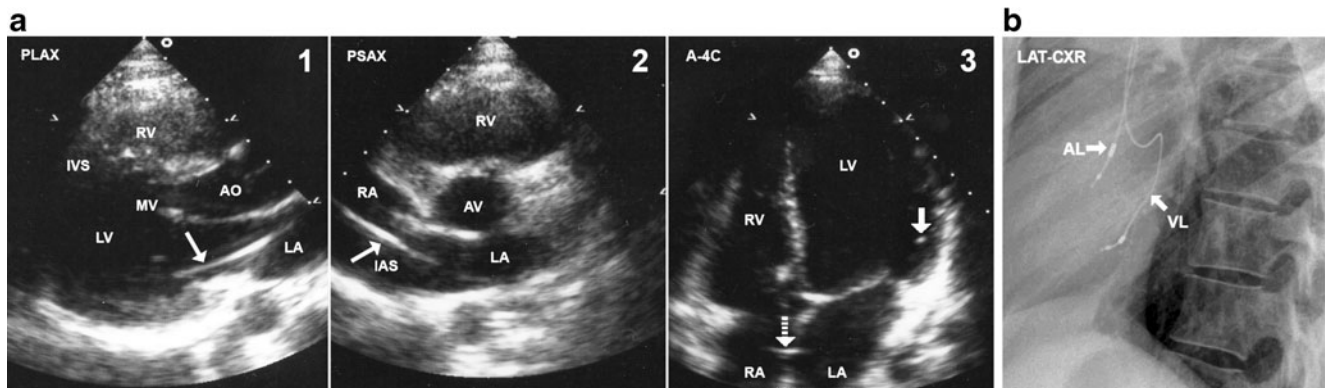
a Transthoracic echocardiogram. 1. PLAX-parasternal long axis, solid arrow-ventricular lead, LA- left atrium, LV- left ventricle, IVS- interventricular septum, RV-right ventricle, MV-mitral valve, AO- aorta. 2. PSAX-parasternal short axis, solid arrow- ventricular lead, IAS-interatrial septum. 3. A-4 C-apical 4
